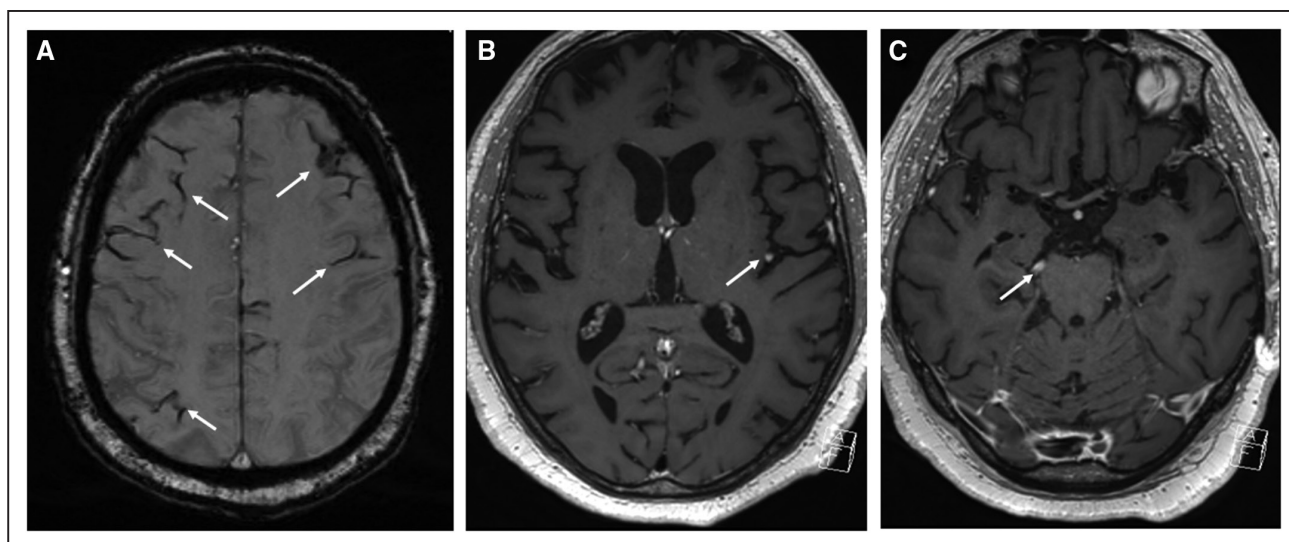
Magnetic resonance imaging (MRI) findings in patient 2.
